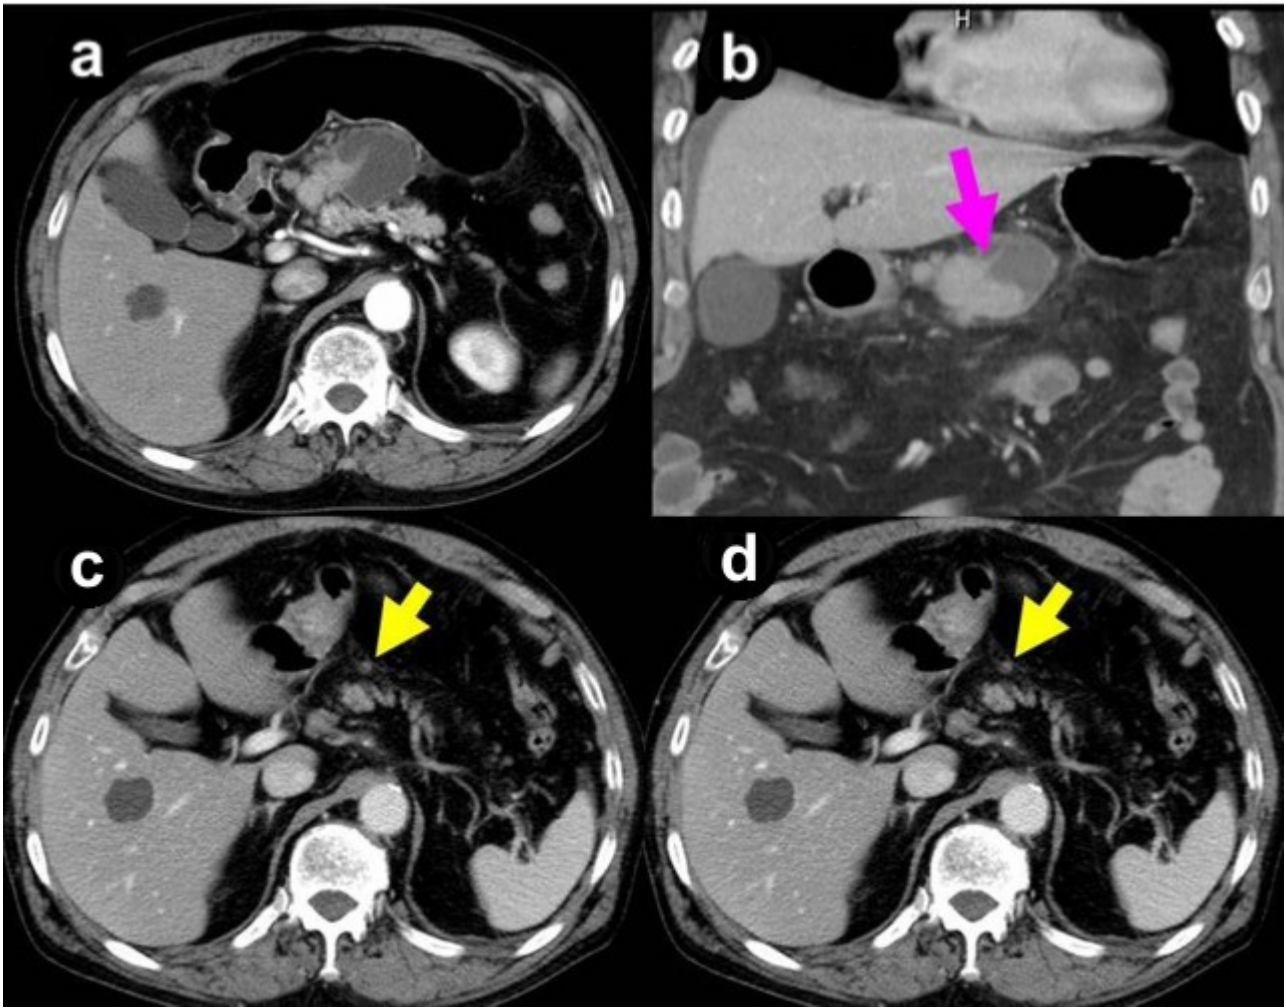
CT scan prior to (a, b.) and during chemotherapy (c.), and prior to operation (d.).
